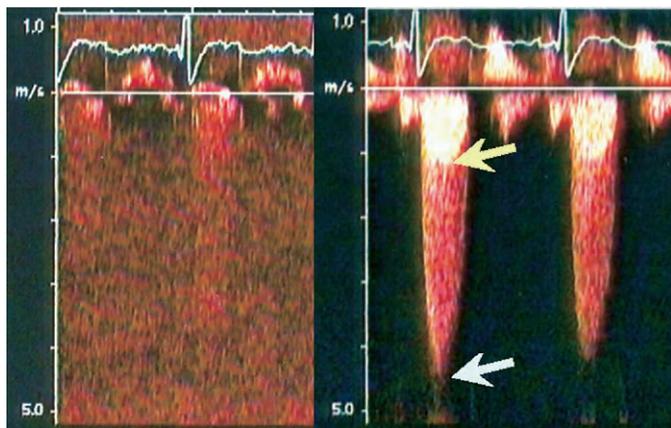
Contrast enhancement of aortic stenosis signal in a patient with a systolic murmur being evaluated for noncardiac surgical risk. Images show continuous-wave Doppler profile from apical window before (*left*) and after (*right*) contrast enhancement. The LV outflow tract spectral Doppler profile is clearly seen within the aortic valve spectral Doppler profile. Despite instrument optimization, the *left panel* shows only faint visualization of the velocity profile; the *right panel* after contrast enhancement shows not only peak transvalvular velocity (*white arrow*) but also subvalvular velocity (*yellow arrow*).
